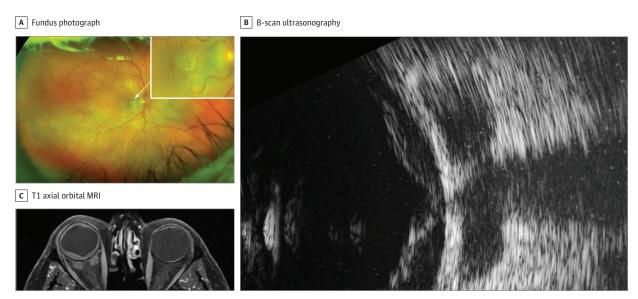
A, Fundus photograph of the right eye showing an infratemporal exudative retinal detachment. Inset, Choroidal folds in the macula. B, B-scan ultrasonography demonstrating broad areas of low reflectivity within the sub-Tenon space and around the optic nerve in addition to the presence of a retinal detachment. C, T1 axial orbital magnetic resonance image (MRI) with gadolinium showing the right eye retinal detachment and revealing an enhancing right optic nerve mass
